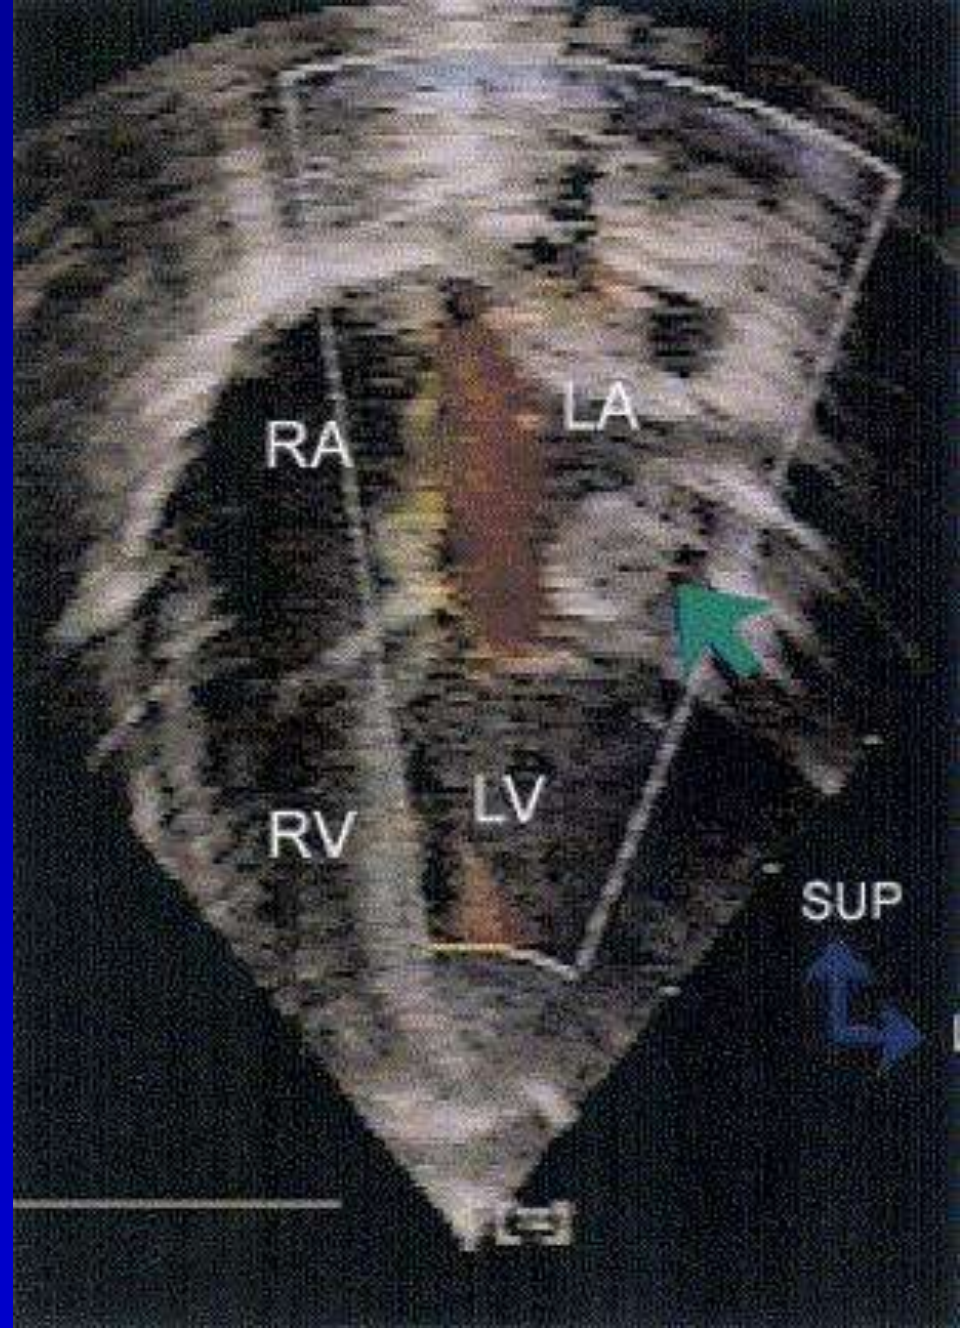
Images taken from 4 views demonstrating the inverted left atrial appendage (LAA) (green arrow), in the left atrium (LA) yellow arrow is pointing to mitral valve (MV). Parasternal long-axis (A), parasternal short-axis (B), apical 4-chamber (C), and subcostal sagittal (D) views
